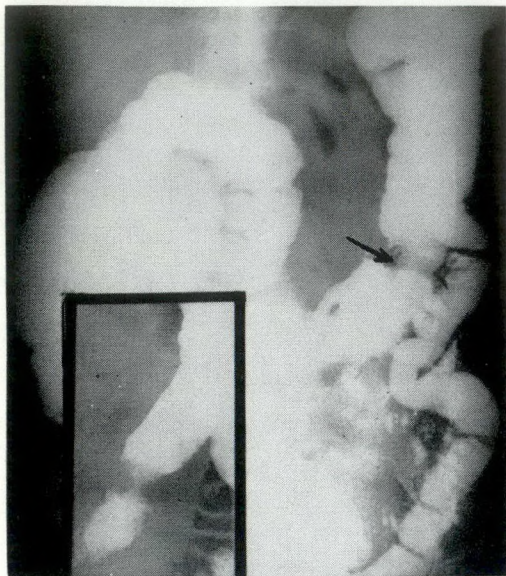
Case 2: The large roentgenogram and the spot film in the insert reveal a narrowed segment in the left transverse colon.
